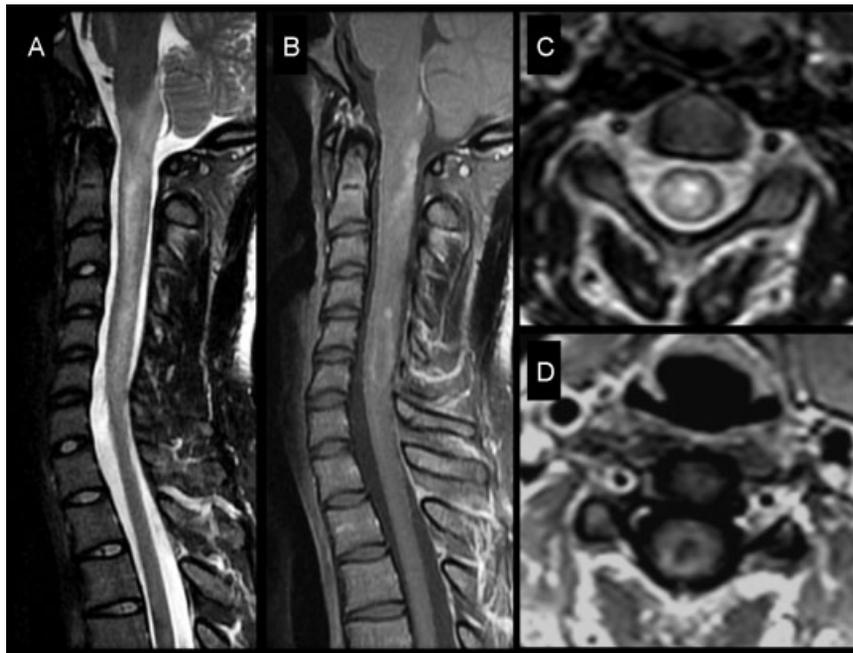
Neuromyelitis optica. Magnetic resonance images shown include sagittal T2 (A), sagittal gadolinium-enhanced T1 (B), axial T2 (C), and axial gadolinium-enhanced T1 (D). Longitudinally extensive T2 signal abnormality in the cervical cord (A,C), accompanied by patchy intramedullary enhancement on gadolinium-enhanced T1-weighted imaging (B,D). The patient subsequently developed monocular vision loss and was found to have a positive neuromyelitis optica antibody.
